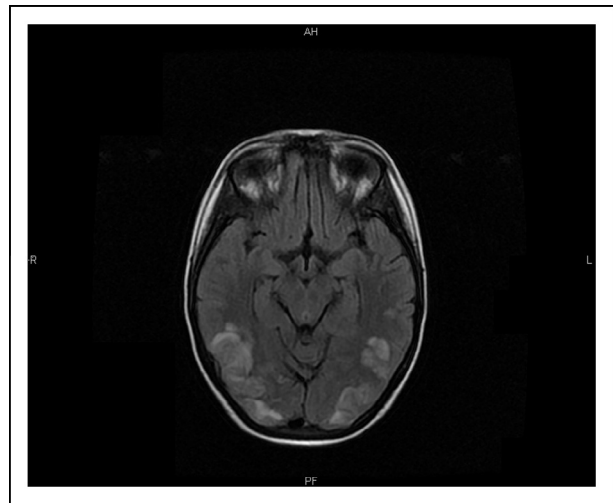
Cerebral magnetic resonance imaging showed a wide signal intensity abnormality involving the fronto-parietal and occipital cortex as well as the subcortical white matter.
